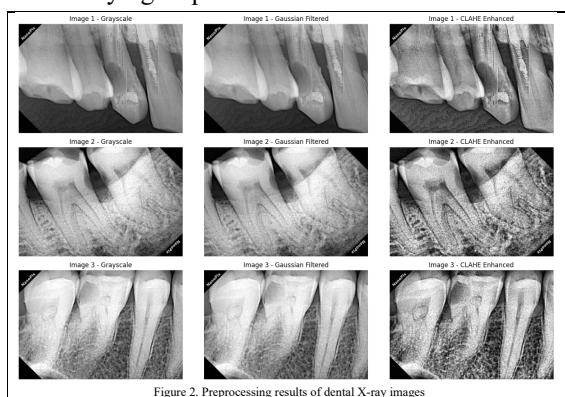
Preprocessing results of dental X-ray images
